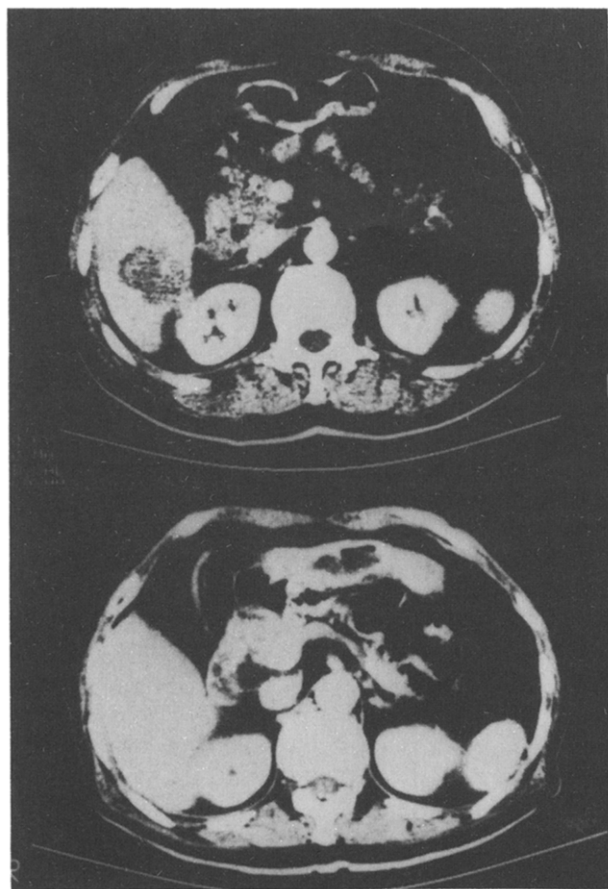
CT scan of the liver in case 9. Top = demarcated tumour in upper anterior segment of right lobe. Bottom = 8 weeks after intratumoral injection with 30 KE OK432.
